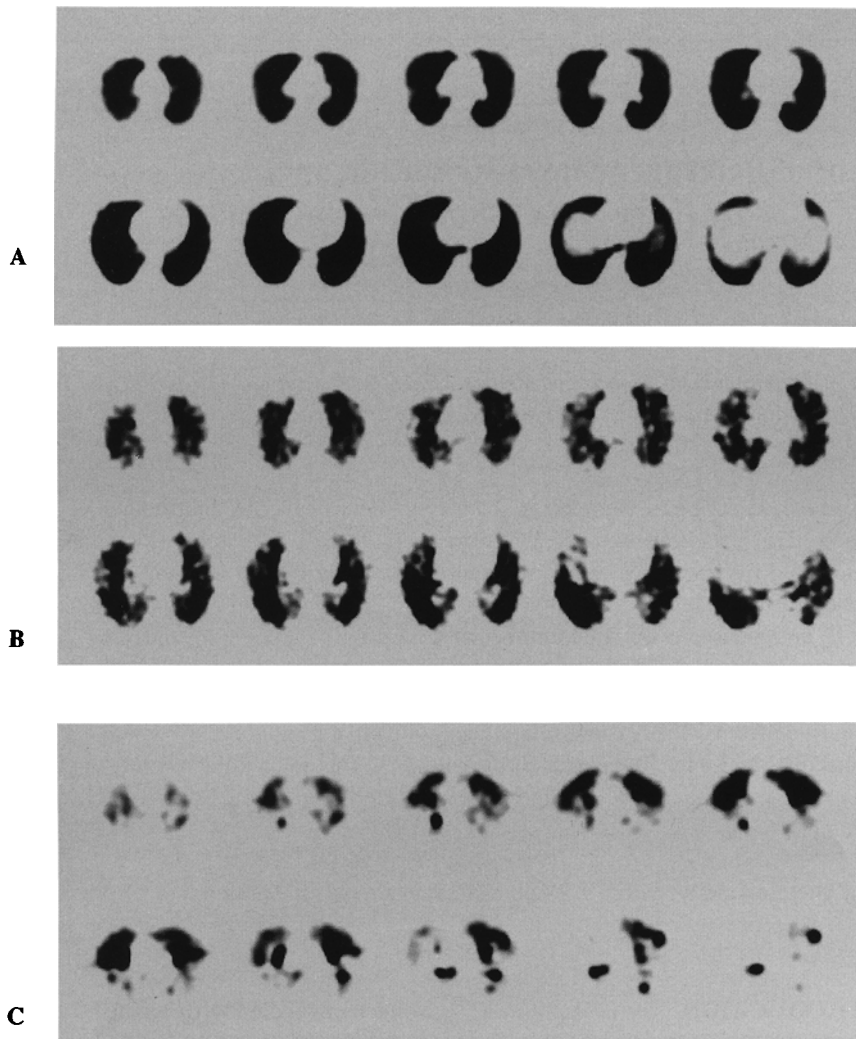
A: 45-year-old healthy male. Technegas SPECT images show homogeneous distribution in whole lung. His fractal dimension for total lung is 0.46. B: 65-year-old male with mild emphysema. Technegas SPECT images show heterogeneous distribution in whole lung. His fractal dimension for total lung is 0.79. C: 63-year-old male with severe emphysema. Technegas SPECT images show heterogeneous distribution of cold and hot spots throughout peripheral lung field. His fractal dimension for total lung is 2.54.
